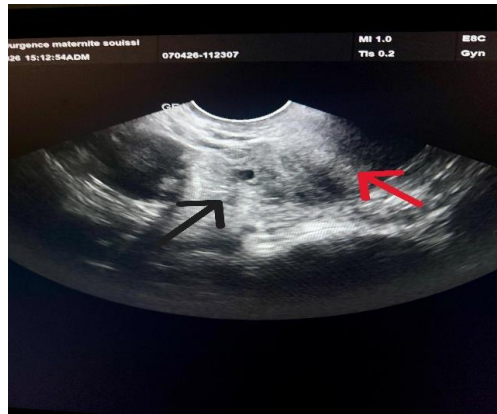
Transvaginal ultrasound showing an eccentrically located gestational sac within the left cornual region (white arrow), uterus (red arrow).
